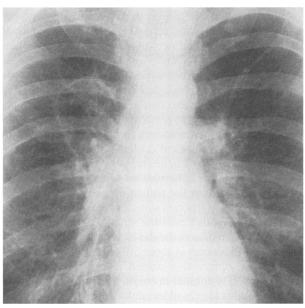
The chest radiograph is from an otherwise healthy patient with pulmonary coccidioidomycosis. Note the thin-walled cavity in the upper lobe of the right lung.
